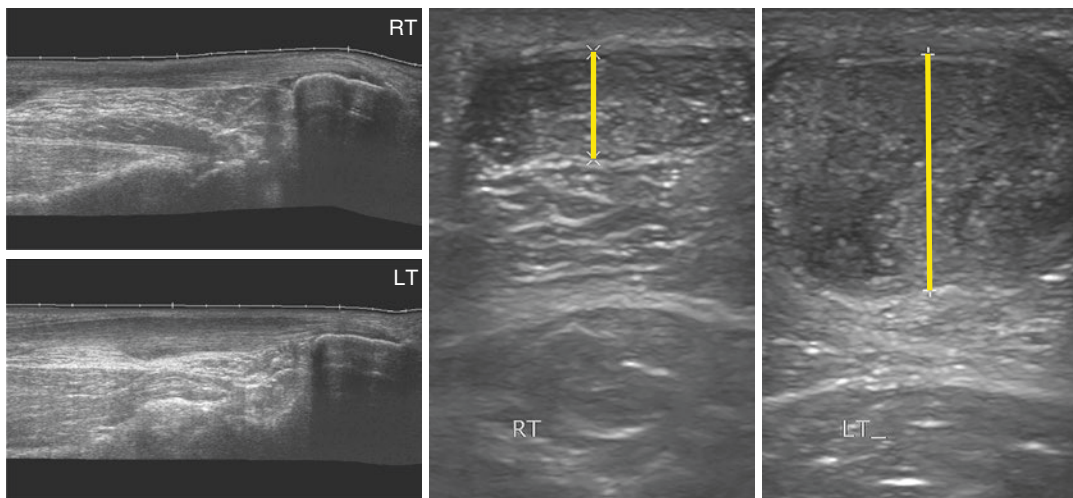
Achilles tendon sonography, depicting a normal (RT) and thickened (LT) achilles tendon, visualized in two orientations
